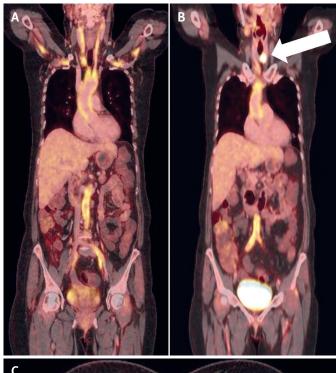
PET/CT performed before patient was admitted to our hospital (with permission of Multiscan, s.r.o. database). A: An uptake of ¹⁸F-FDG in the aortic wall, subclavian arteries, carotid arteries, common iliac arteries, internal iliac arteries; B: An uptake of ¹⁸F-FDG in the left lobe of the thyroid gland in the left lobe of the thyroid gland. Arrow points to a tumour in the thyroid gland; C: Axial view.
